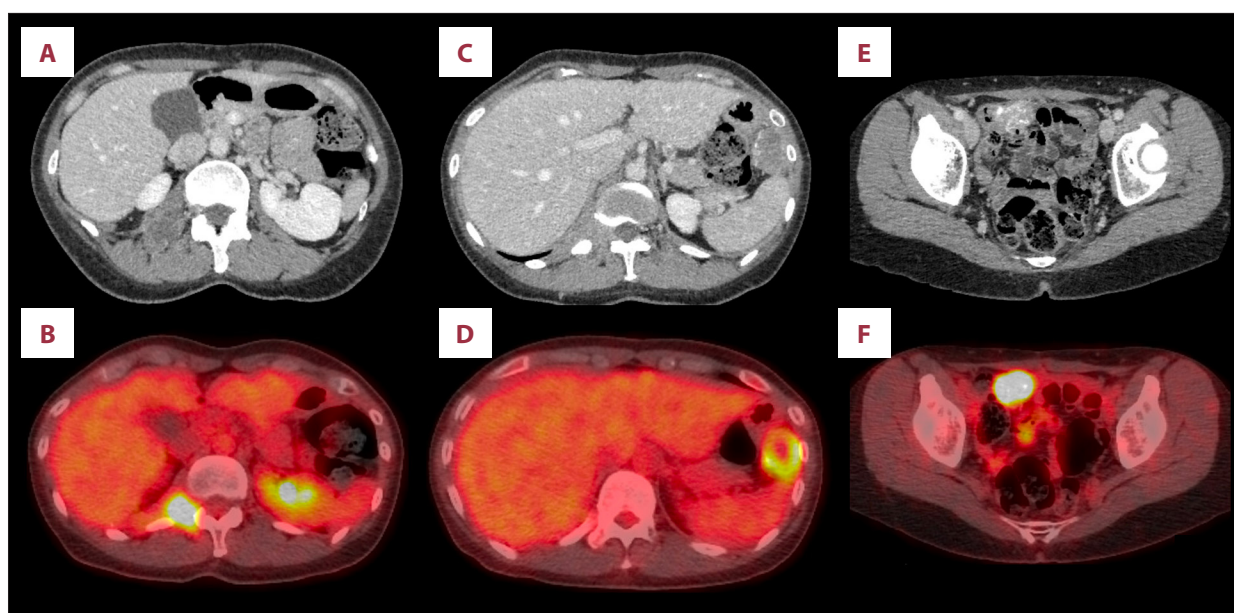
Findings on CT and PET-CT on the recurrent tumors. (A, B) images of right quadratus lumborum muscle metastasis, (C, D) images of the recurrent tumor on the greater curvature of stomach and (E, F) images of tumor near the ileocecal region. (A, C, E) contrast-enhanced CT images and (B, D, F) PET-CT images.
